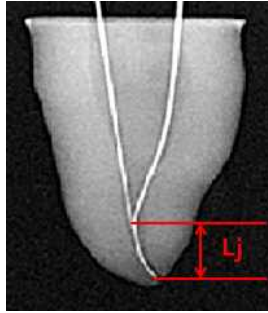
Lj on radiograph.
